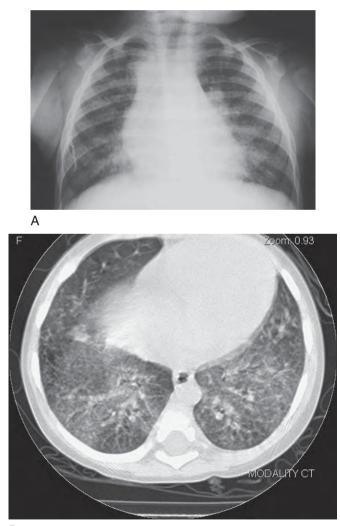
A, Chest radiograph of a child with lymphocytic interstitial pneumonia (LIP) with multiple nodular densities throughout all lung fields. The nodules are larger centrally than peripherally. Also noted are hilar adenopathy and widening of the mediastinum. B, High resolution chest CT scan of a child with LIP showing a diffuse micronodular pattern. (A, Courtesy Henry Pritzker, Bronx, NY.)
